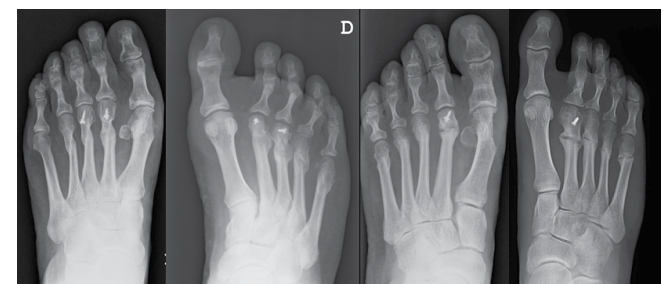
Preoperative radiographs of patients with persistent metatarsalgia following open surgery with Weil osteotomies.
